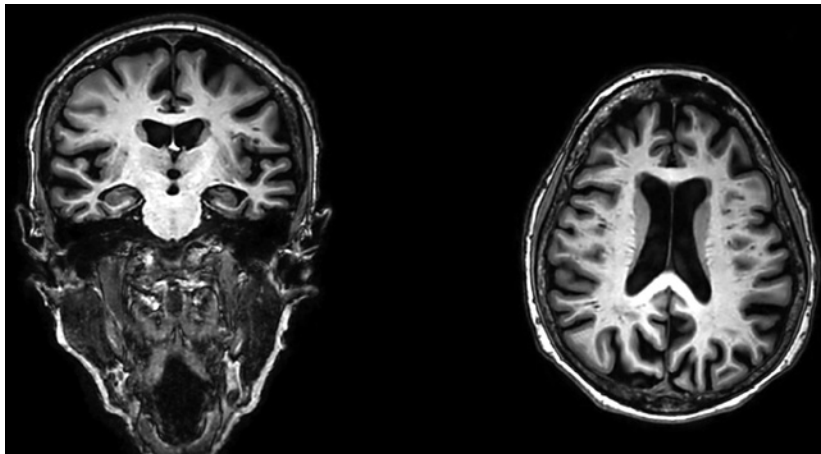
Brain MRI of patient 2, showing diffuse atrophy, more evident on anterolateral temporal, inferior-lateral frontal, and superior-lateral parietal convexities.
